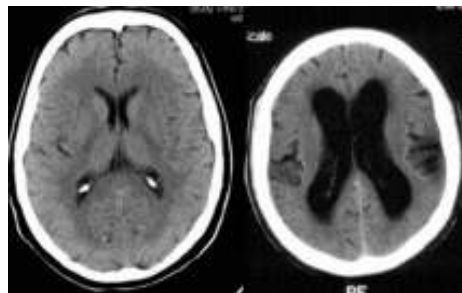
CT images of a normal brain (left, [3]) and a brain with NPH (right, [4]).
